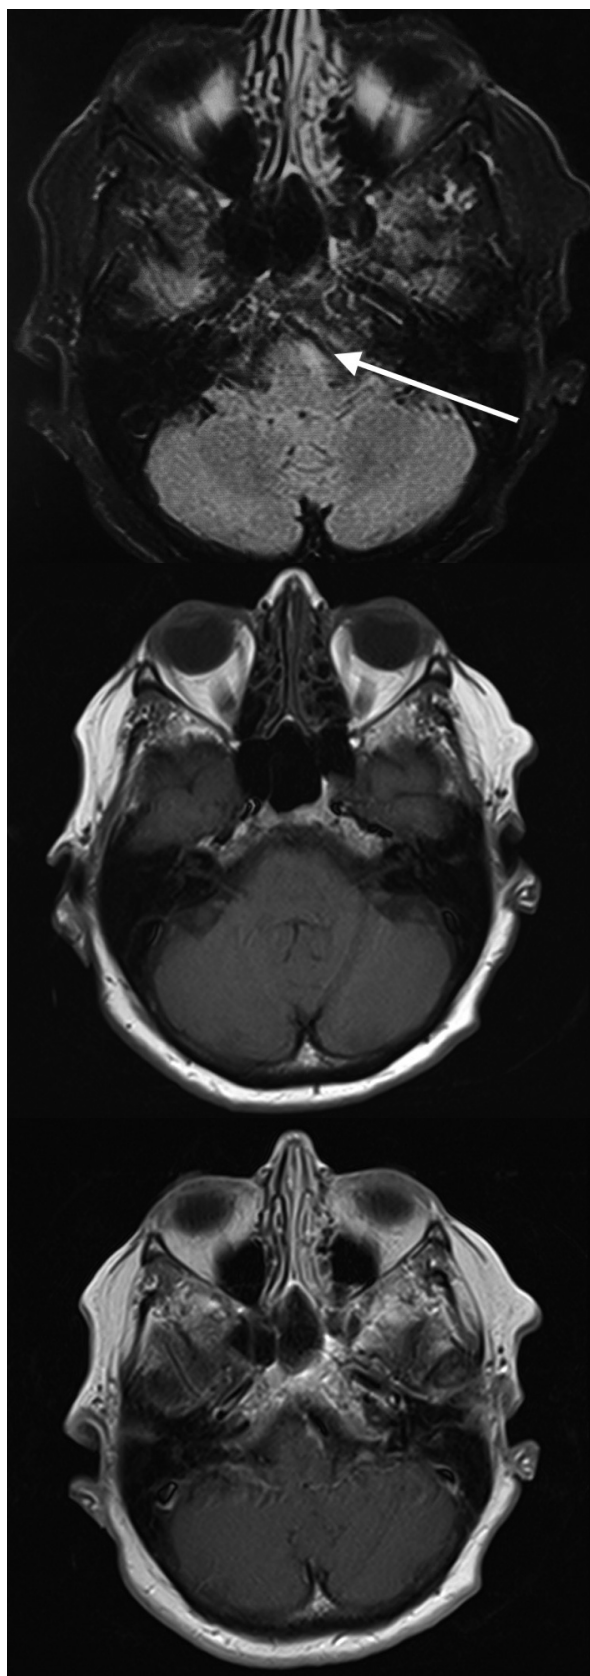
Case 2. MRI scan showing FLAIR and T1 images before and after contrast, with linear enhancement after contrast in the ventral left part of the medulla oblongata
